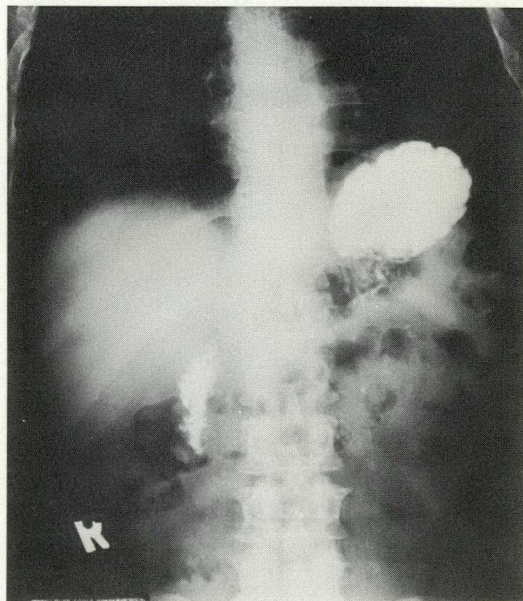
Upper gastrointestinal radiograph, taken 10 days later, shows no sign of cyst.
